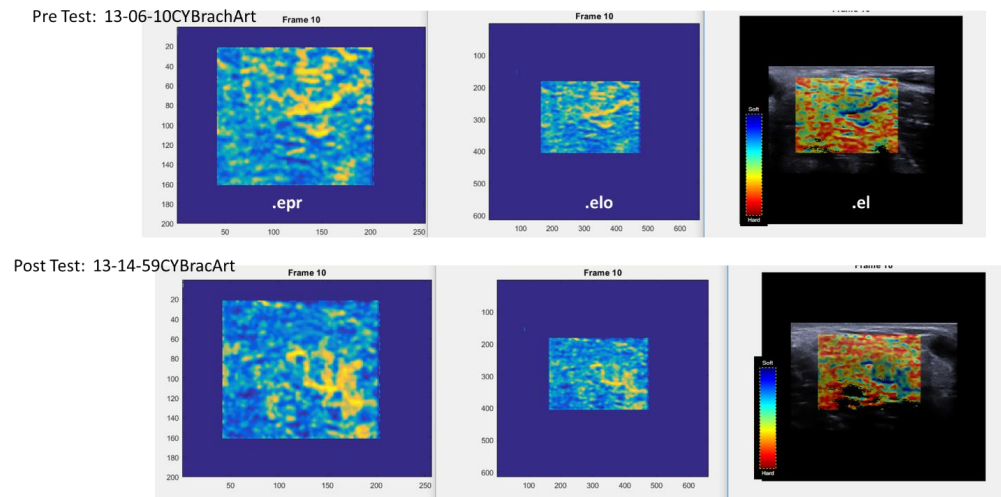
Elastography imaging output from BK Ultrasonix. (top row) baseline and (bottom row) after physical exertion. (Left column) Pre-scan converted. (middle column) scan converted, (right column) scan converted B mode image superimposed color overlay on segmented region, where reds correspond to hard tissue and blue corresponds to soft tissue.
